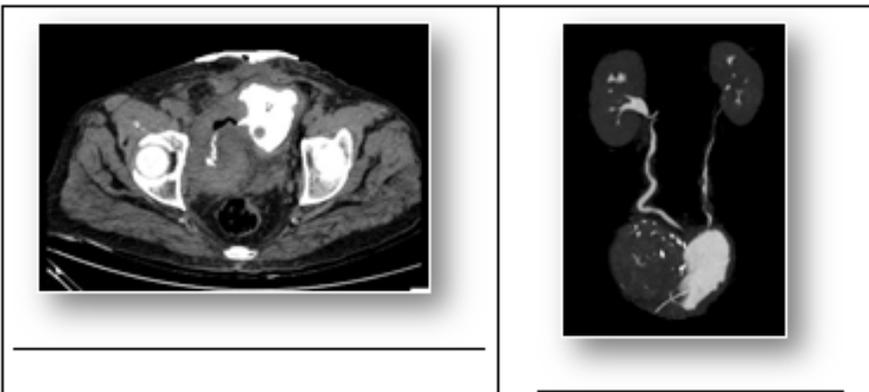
Axial excretory phase CT image showing contrast opacified bladder with thickened walls communicating posterolaterally on the right side with a large soft tissue density lesion. The bladder was shifted anterolaterally by this mass. This was large bladder diverticulum with malignant transformation. Fig 22: Coronal MIP CT Urographic image showing the large mass displacing the bladder towards the left.
